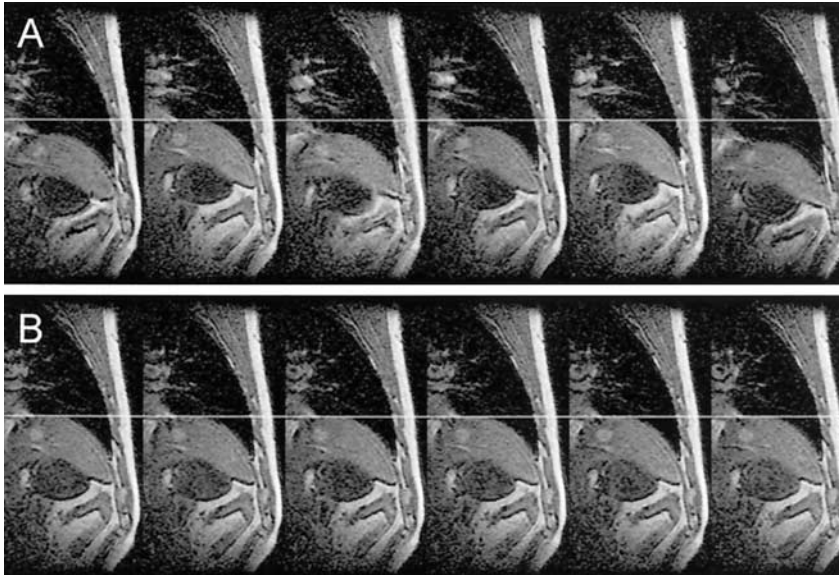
Six serial MR images of the liver in the sagittal plane without (A) and with (B) respiratory triggering acquired with a SPGR (14/3.7: TR/TE). The acquisition time for one image was 1.8 s. The images without triggering (A) were acquired consecutively under the artificial ventilation. To indicate the top positions of the diaphragm, white lines were added at their highest locations in individual series. The tumor was visualized with high intensities.
